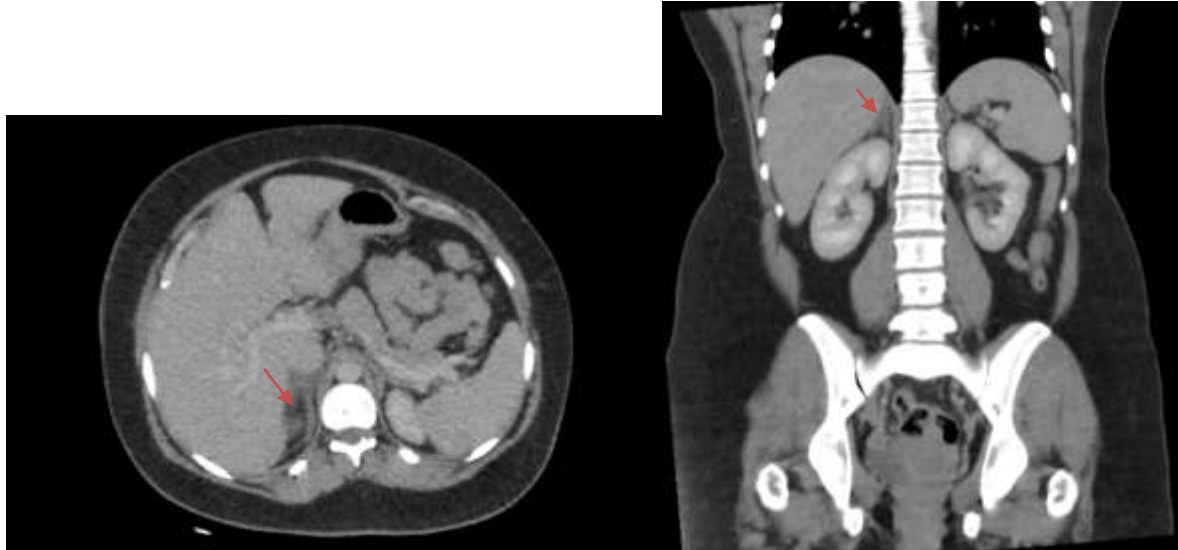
Injected thoraco-abdomino-pelvic CT scan showing thrombosis of the right adrenal vein associated with edema.
